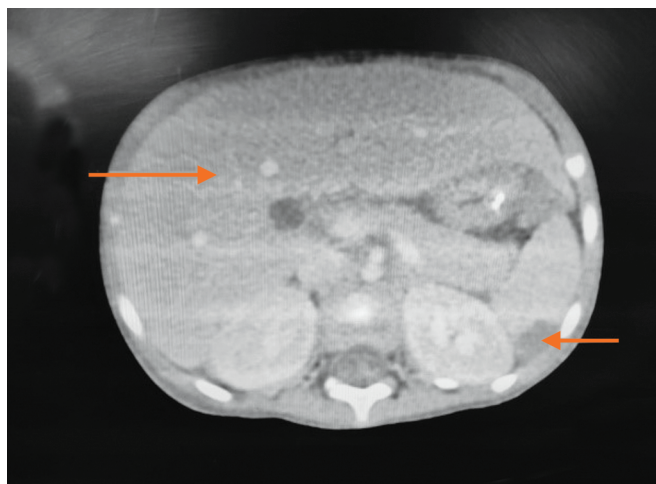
CT abdomen showing hepatomegaly and splenic abscess
